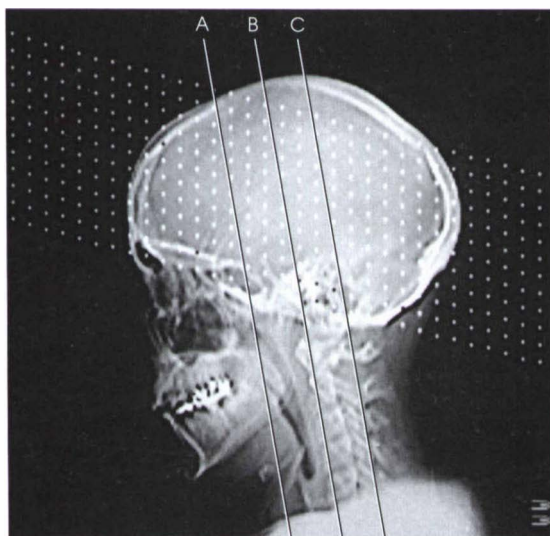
CT localizer (scout) image of the skull.
